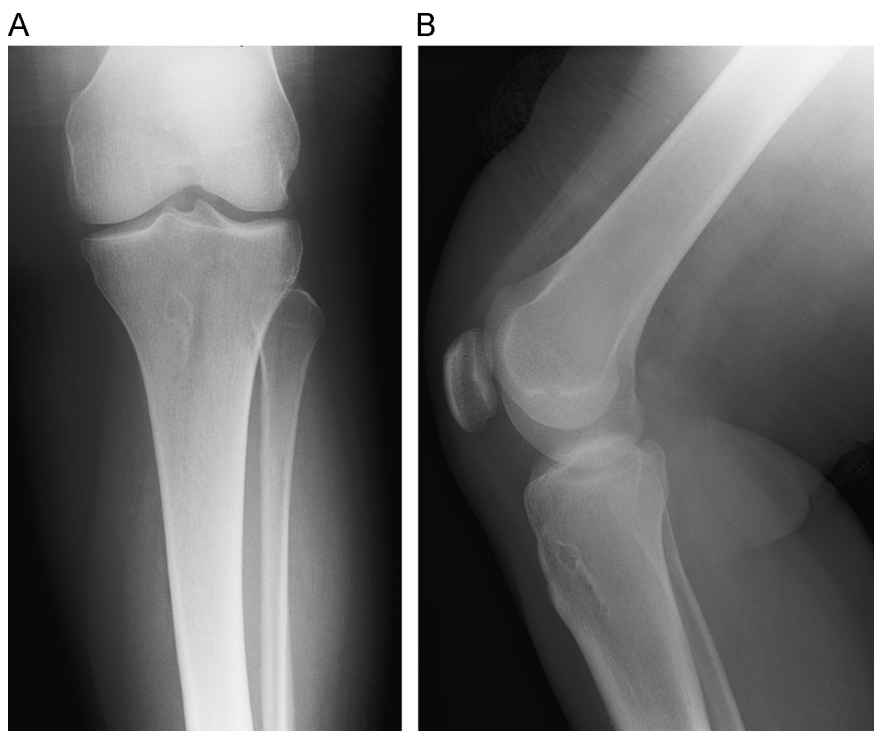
Anteroposterior (A) and lateral (B) radiographs of the proximal tibia demonstrating a well-bordered lytic lesion with a sclerotic rim.
